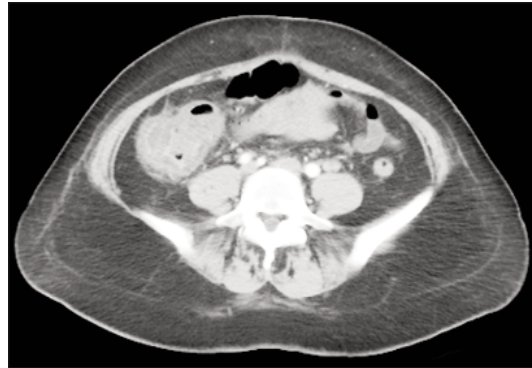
The second abdominal CT- prior to surgery. Parietal changes with an inflammatory-infectious substrate.
